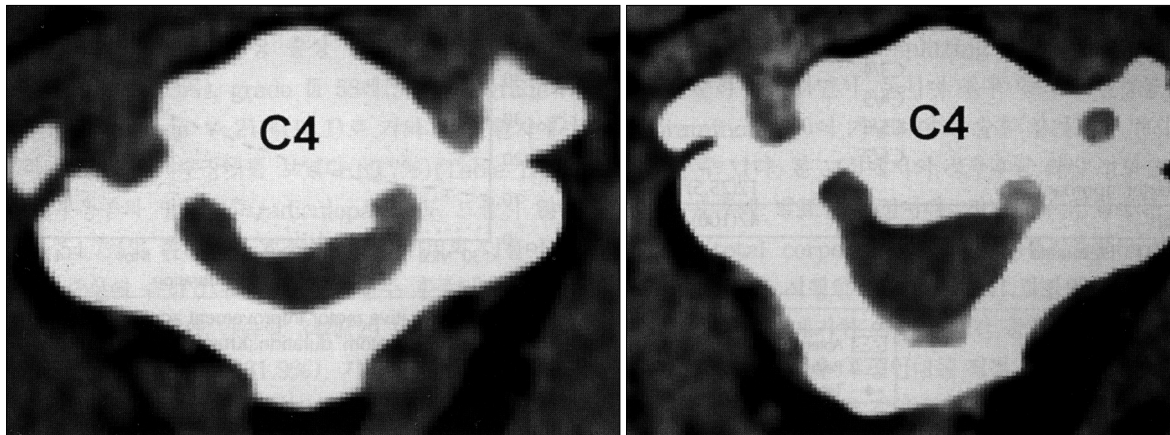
Pre-operative cervical CT scan demonstrate OPLL which compresses spinal cord at 4th cervical vertebral level. Post-operative cervical CT scan show spinal canal expansion after cervical expansive laminoplasty.
